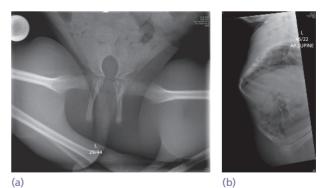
Sacral agenesis (a) AP pelvis and (b) lateral spinal radiographs of a young girl with severe sacral agenesis. Her hips are in wide abduction and she sits in a Buddha position. The two iliac wings are fused together and there is no sacrum; in addition, the lateral view confirms there is no lumbar spine either. She has essentially no motor or sensory function below L2. finally the long period of residual paralysis. The disease strikes at any age but most commonly in children.
